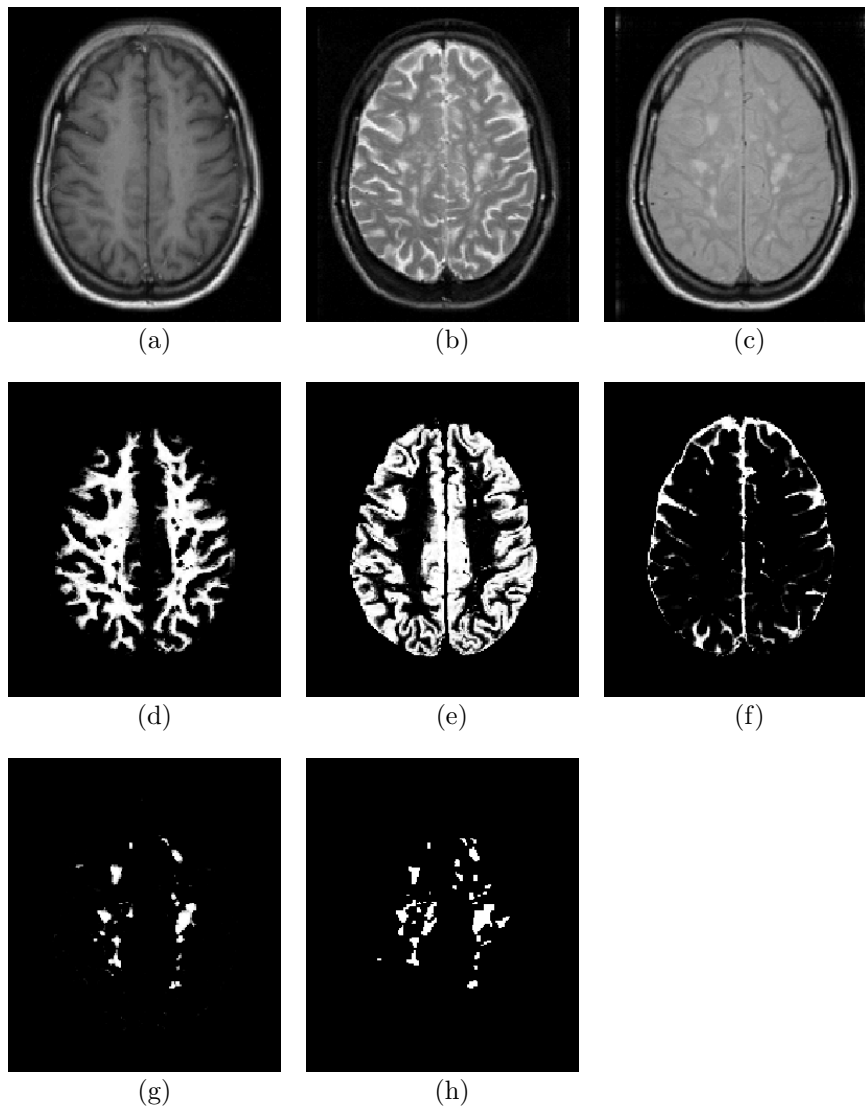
Automatic classification of one of the 20 serial data sets that were also analyzed by a human expert. T1-weighted image (a); T2-weighted image (b); PD-weighted image (c); white matter classification (d); gray matter classification (e); CSF classification (f); MS lesion classification (g); and expert delineation of the MS lesions (h). (Source: Publication III)
